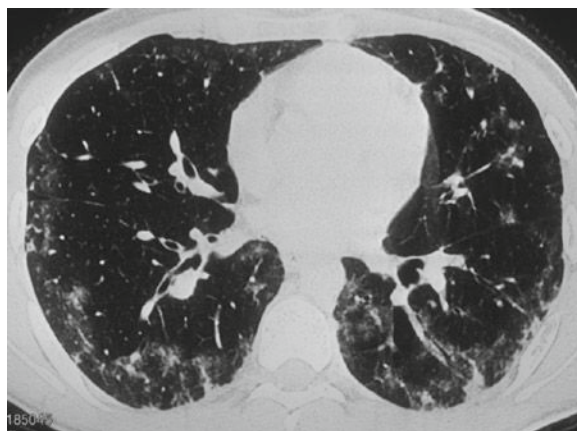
A 28-year-old male after allogeneic re-transplantation for chronic myelogenous leukemia. HRCT was performed on post-transplantation day 91 to evaluate a fever with a cough and dyspnea. Peripheral intralobular septa (arrow) and ground-glass opacities were seen. The tree-in-bud pattern (arrowhead) suggests bronchiolitis obliterans. Acute GvHD was diagnosed by a transbronchial biopsy. The immunosuppressive treatment regimen was stepped up, after which the clinical symptoms and radiological signs disappeared. Note the similarity to Fig. 12.15
